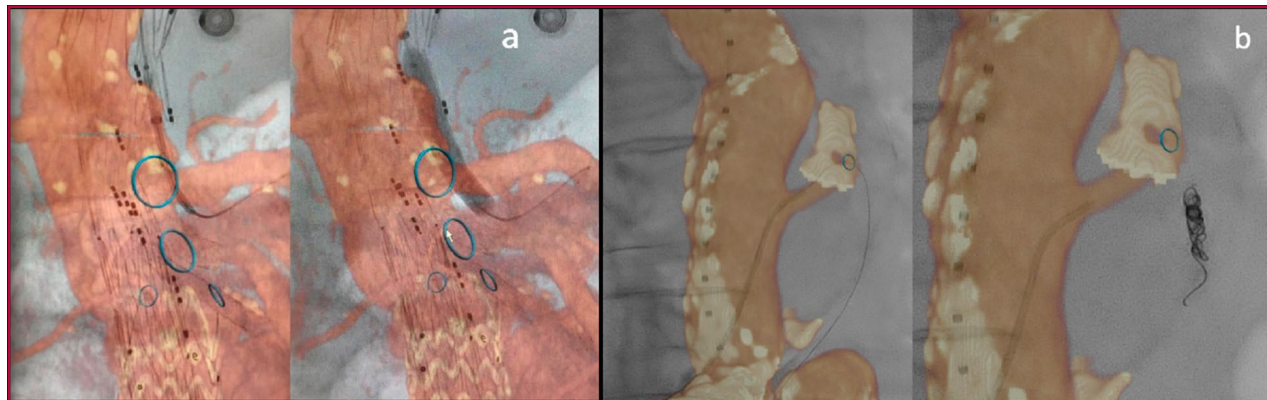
Two sequences in which fusion imaging was used. On the left (a), the orange image –corresponding to the previous CT-angiography– is merged with the gray image –corresponding to the live angiography. The celiac trunk is cannulated in the case of a branched stent-graft. On the right (b), the light-blue ring shows the origin of the inferior mesenteric artery to be embolized with coils to avoid type II endoleak
